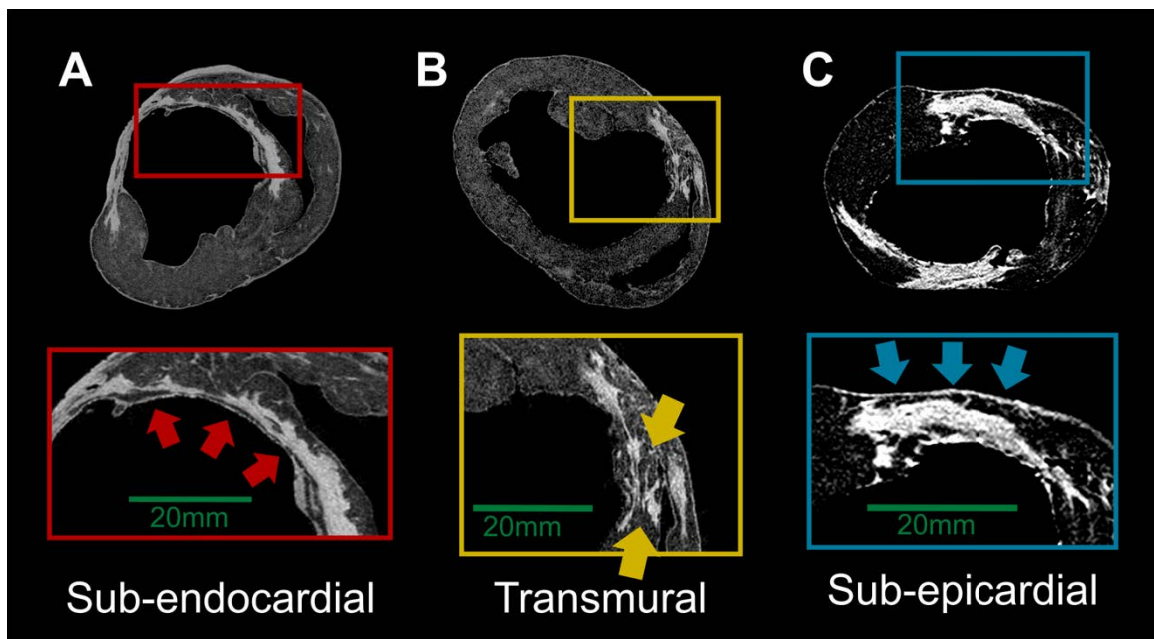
Delineation of viable tissues in the vicinity of the scar using short-axis slices of high-resolution LGE-MRI in hearts 5,7 and 8 (A) Thin sub-endocardial layer of viable tissue (red arrows), (B) transmural viable tissue located inside the infarct (yellow arrows) and (C) sub-epicardial layer of surviving myocardium (blue arrows). The layer of surviving myocardium at the sub-endocardium has heterogeneous thickness throughout the cavity.
